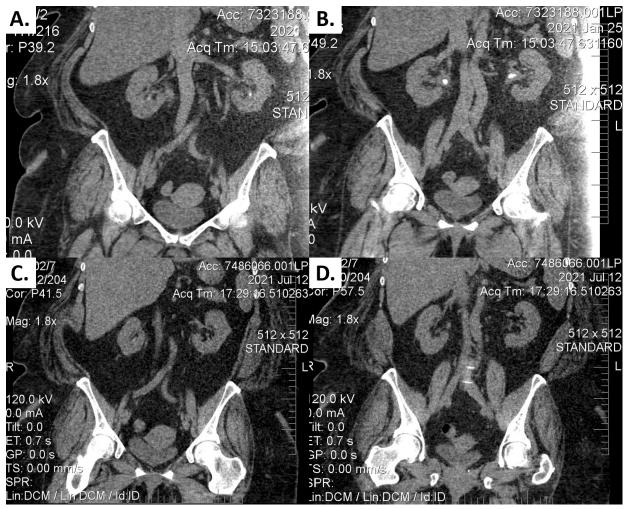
Abdominal computed tomography (CT) of a patient with bilateral uric acid kidney stones before (A,B) and after (C,D) administration of Qsymia[®] 7.5 mg/46 mg. (A,B) Coronal CT sections demonstrating lower pole and renal pelvis calculi (red arrows). (C,D) Coronal CT demonstrating complete stone dissolution after 3 months on phentermine 7.5 mg/topiramate 46 mg (Qsymia[®]).
